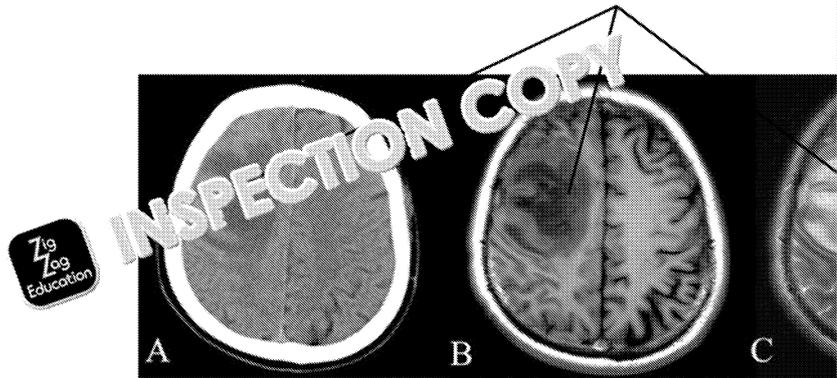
CT (image A) and MRI scans (images B and C) showing a lesion in the brain.
